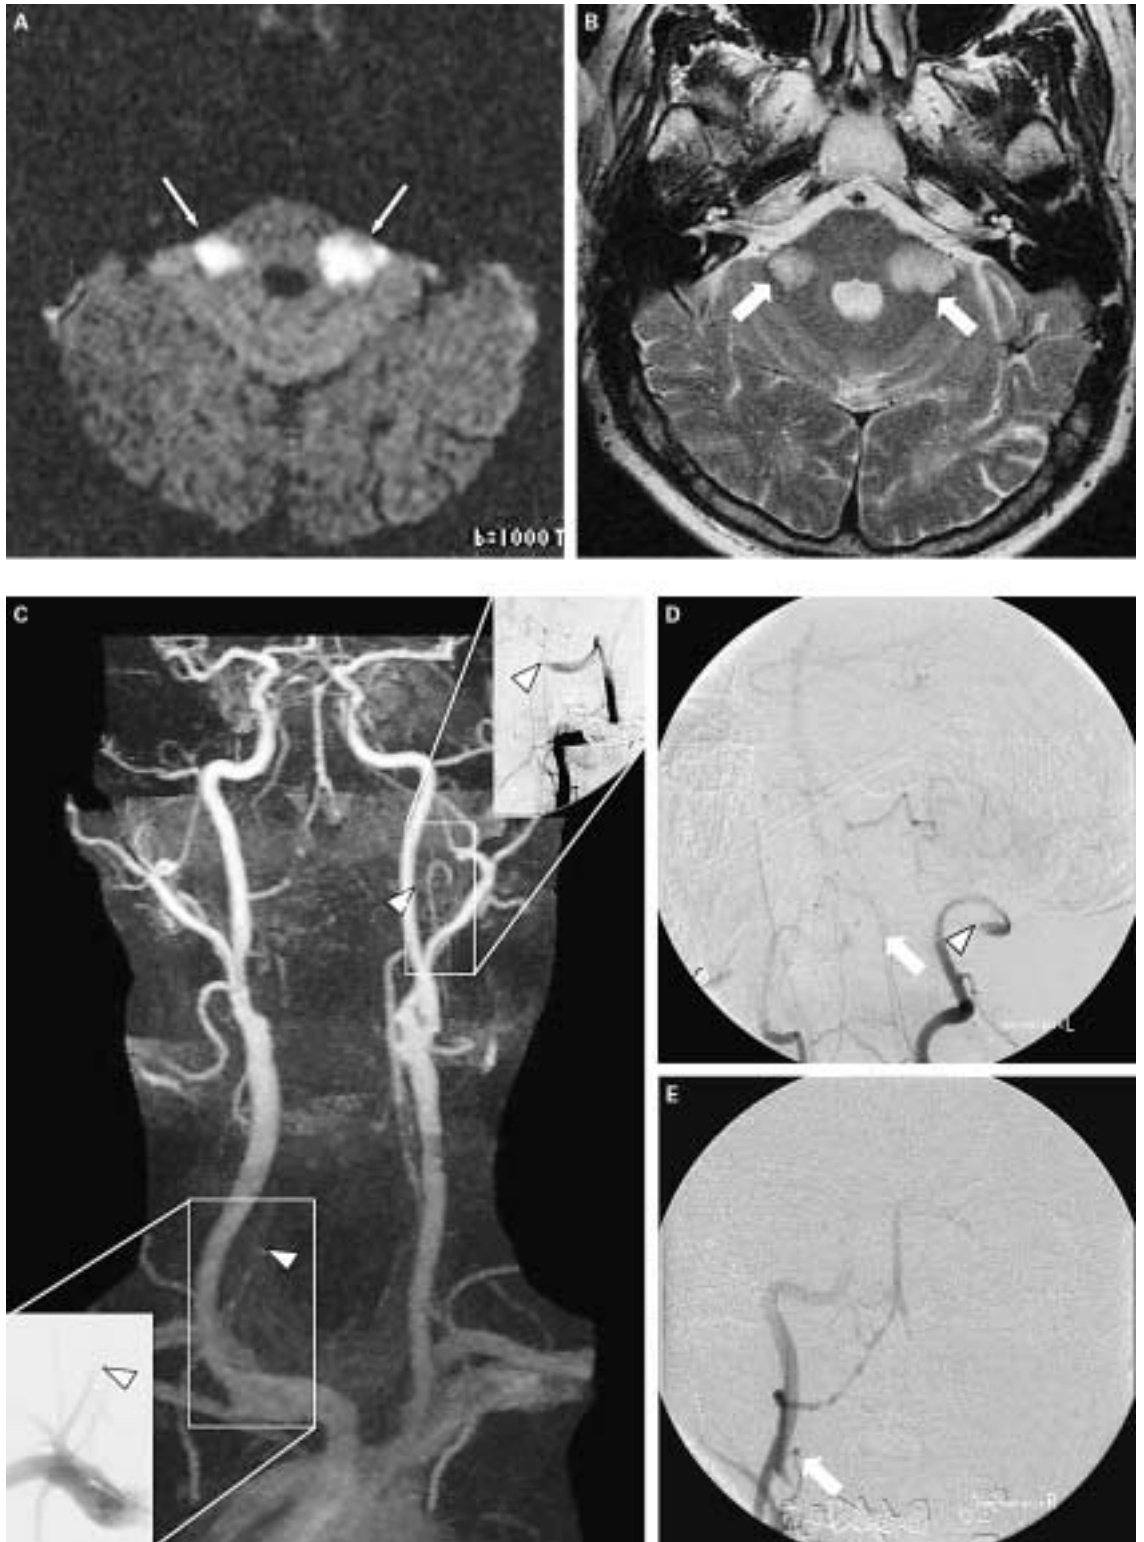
A, B Cranial magnetic resonance imaging revealed bilateral middle cerebellar peduncular infarctions (A, arrows, diffusion-weighted MRI, $b = 1,000$; B, arrows, T2 MRI) and an infarction in the flocculus on the left side. All infarcts were confined to the territory of the anterior inferior cerebellar arteries. C–E Vertebral angiography showed occlusion of the right and left vertebral arteries (C, arrowheads) and collateralization of both vertebral arteries (D, E, arrows).
